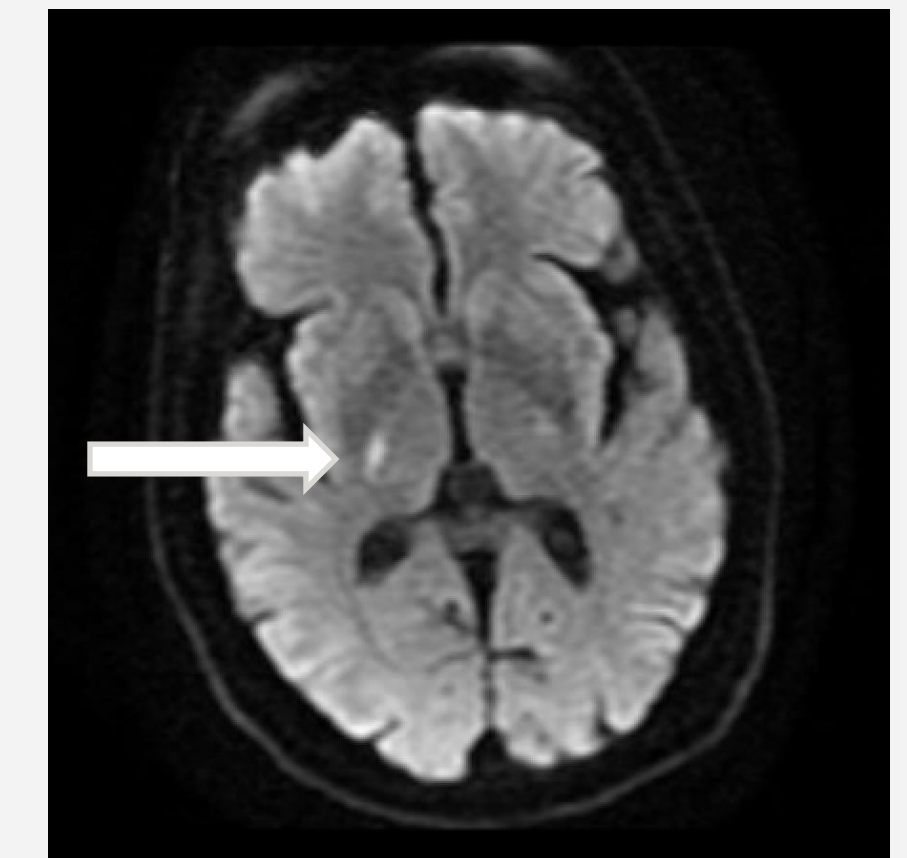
Acute ischemic stroke of the right internal capsule, posterior limb on brain MRI
